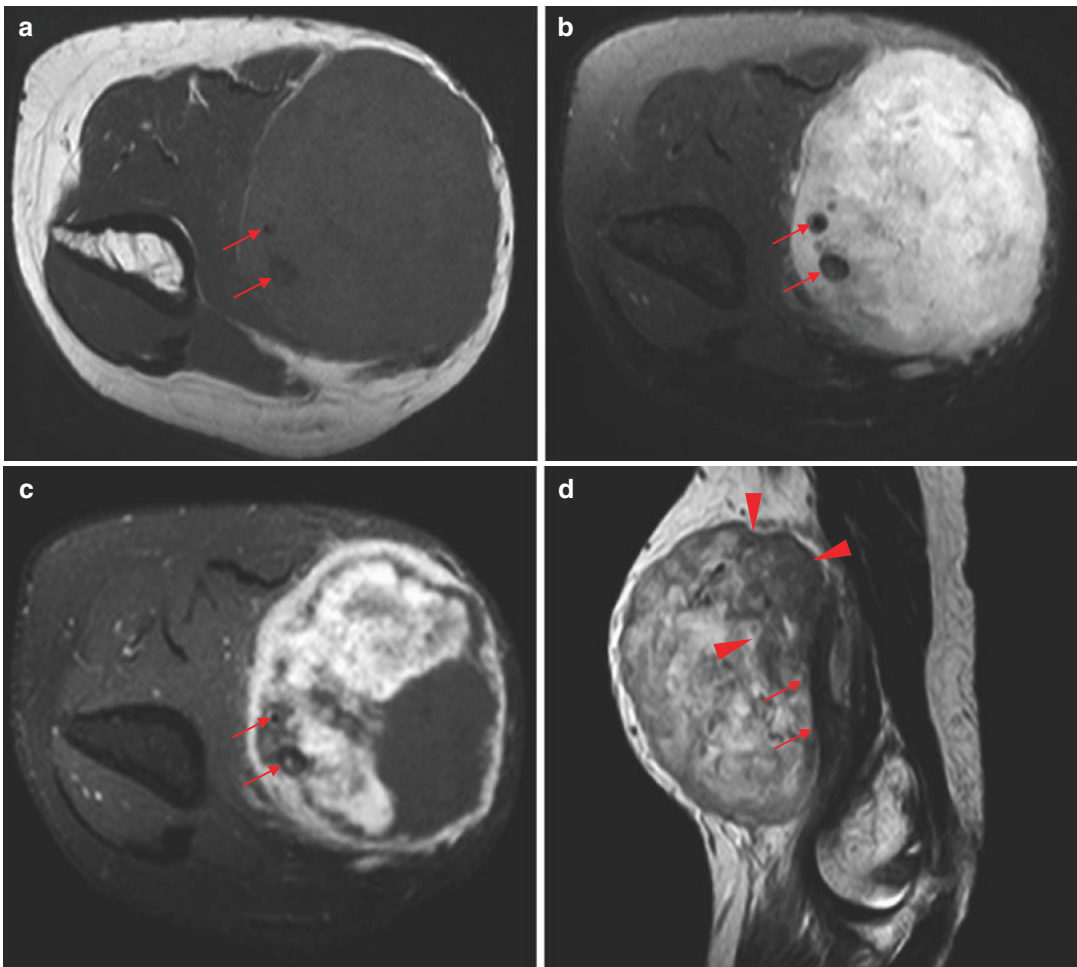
Epithelioid hemangioendothelioma. MR image of the elbow reveals a circumscribed intermuscular soft tissue mass in the subfascial location of the distal upper arm. The lesion shows mild hyperintensity to muscle on T1WI (a), hyperintensity on FS T2WI (b), and heterogeneous contrast enhancement with large non-enhancing area on post-contrast FS T1WI (c), suggesting hemorrhage or necrosis. The mass encases, but does not compromise, the segmental brachial neurovascular bundles (*small arrows*). Tubular signal voids are
